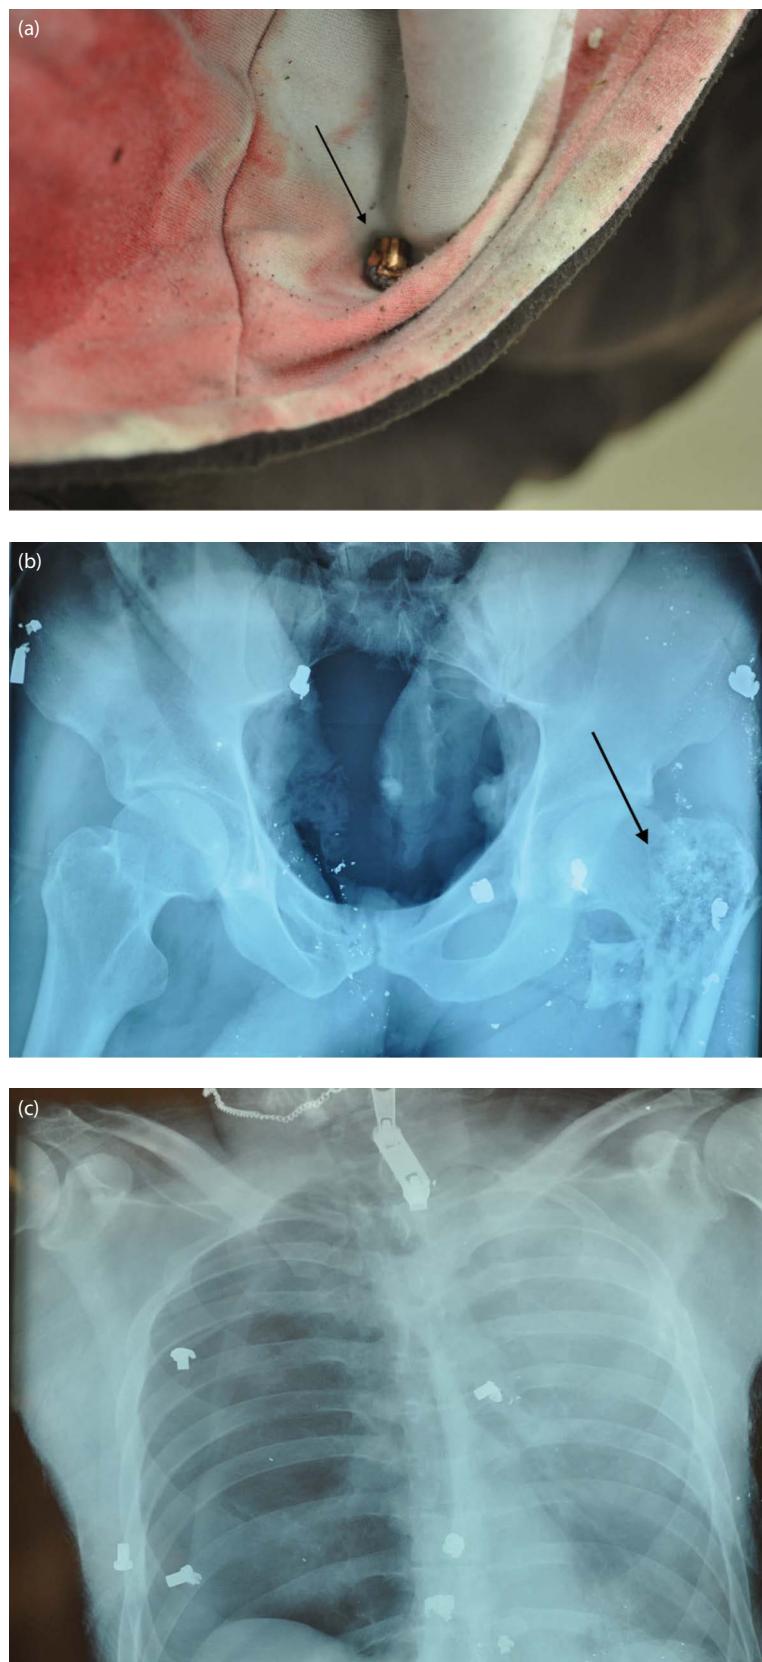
Bullet in clothing. (a) Some articles of clothing can trap bullets. A bullet was found in the hood of a sweatshirt. For this reason, the clothing should be x-rayed and carefully searched, so as not to lose a bullet or other trace evidence. (b and c) X-rays of the pelvis and chest show multiple bullets. The x-rays help with locating the bullets and documenting deep injuries, such as fractures. The arrow in (b) points to a hip fracture produced by the gunshot wound.
